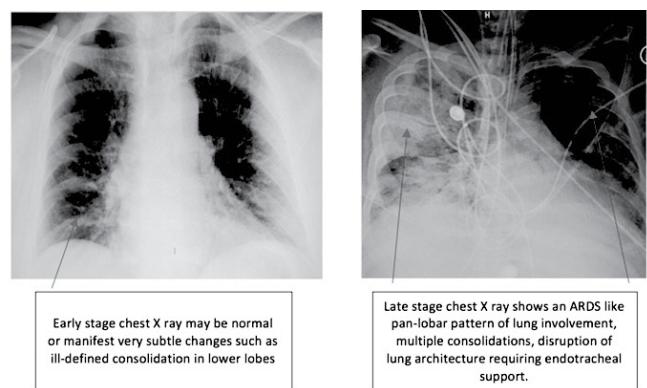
Early and Late stage X-Ray findings of Covid-19 patient [37]
